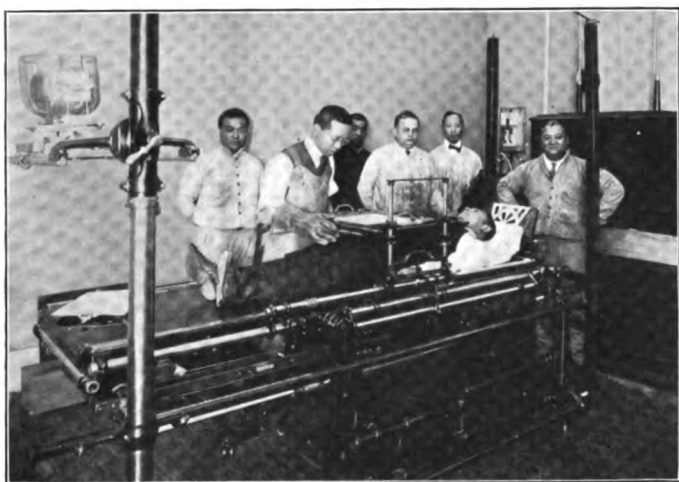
X-ray room, Red Cross General Hospital, Shanghai
